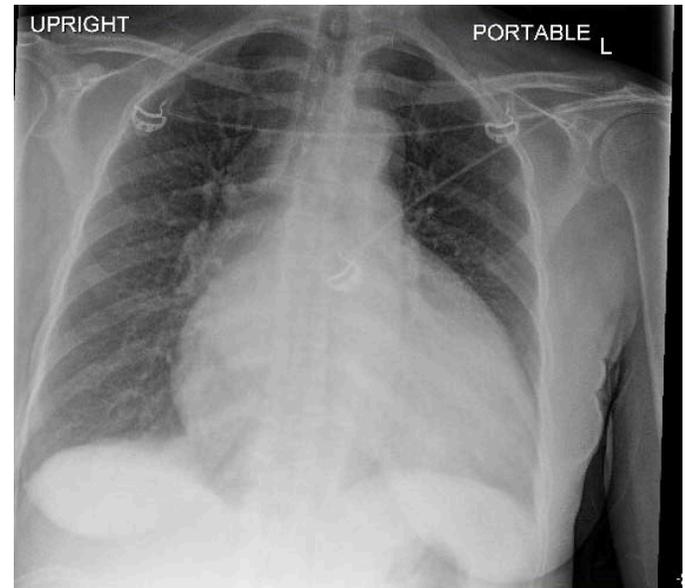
Chest x-ray on presentation with marked cardiomegaly
